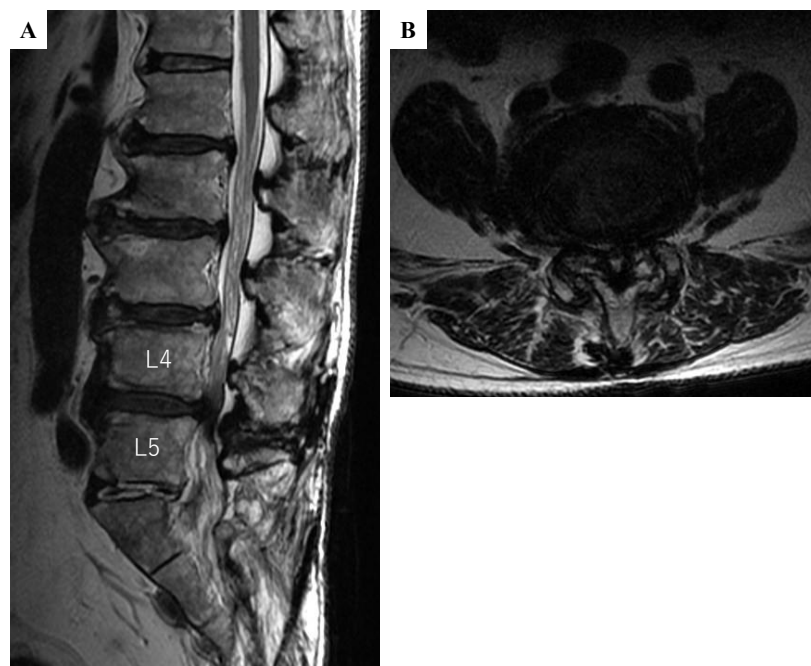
Magnetic resonance imaging (MRI) of the lumbar spine. Sagittal T2-weighted image (WI) (A) and axial T2-WI (B) shows degenerative severe stenosis at L4-L5.
